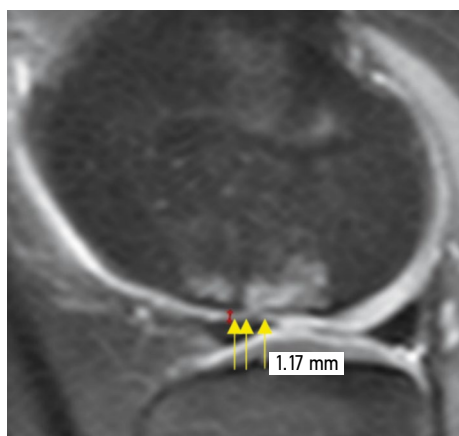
Magnetic resonance imaging of the knee joint (sagittal PD-FS image) of a child with an osteochondritis dissecans lesion. Thinning and hypointensity of the signal from the articular cartilage in the OD lesion are observed. The magnetic resonance picture shows a grade III cartilage damage, according to ICRS
